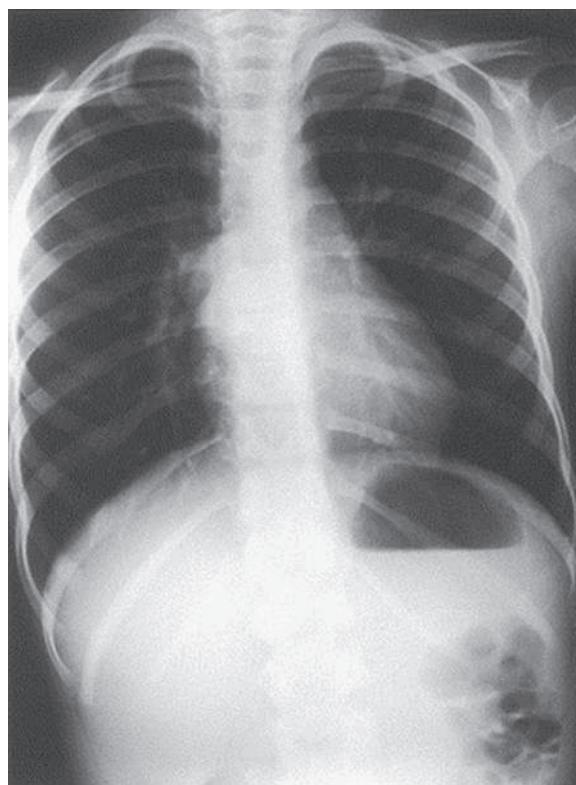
Chest x-ray showing an ovoid, well-defined soft tissue density causing splaying of the carina because of a bronchogenic cyst. (From Williams HJ, Johnson KJ. Imaging of congenital cystic lung lesions. *Paediatr Respir Rev*. 2002;3:120–127.)
